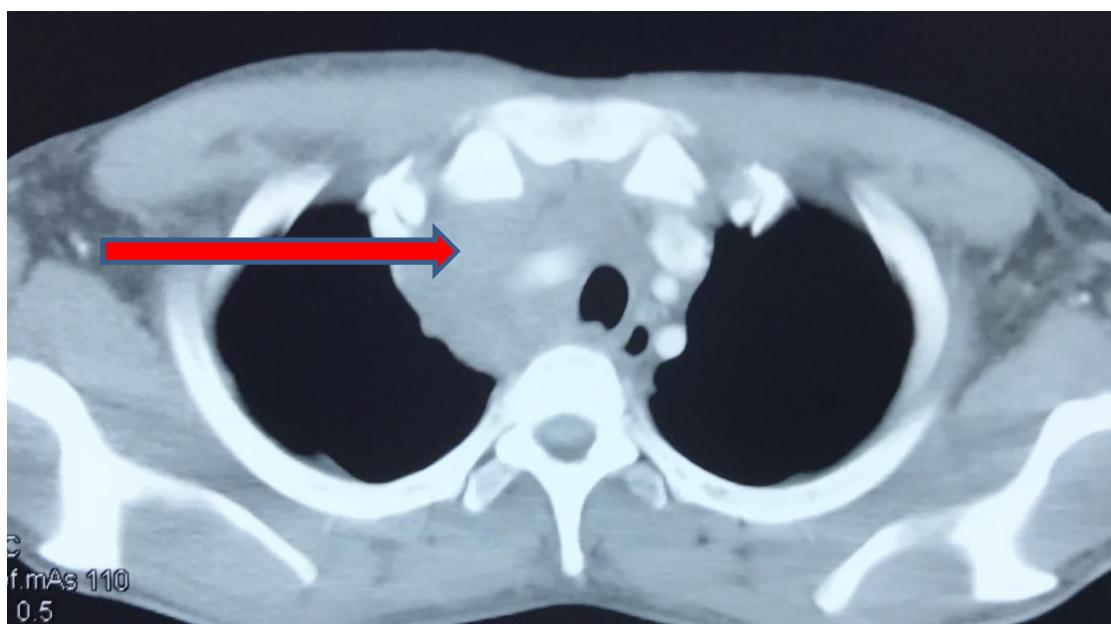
CT imaging showing a large anterior mediastinal mass (red arrow)
